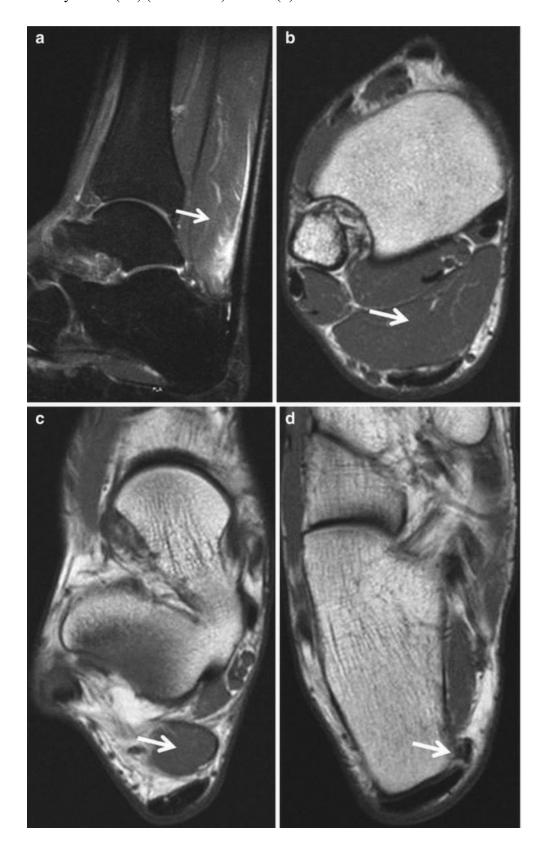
A 25-year-old patient with recurrent pain in the lower leg during athletic activity. Sagittal STIR MRI (a) shows accessory soleus with spontaneous hyperintensity due to muscular strain (*arrow*). Axial T1-weighted MRIs (b-d) show the insertion of the accessory soleus (*arrow*) on the medial aspect of the calcaneus
